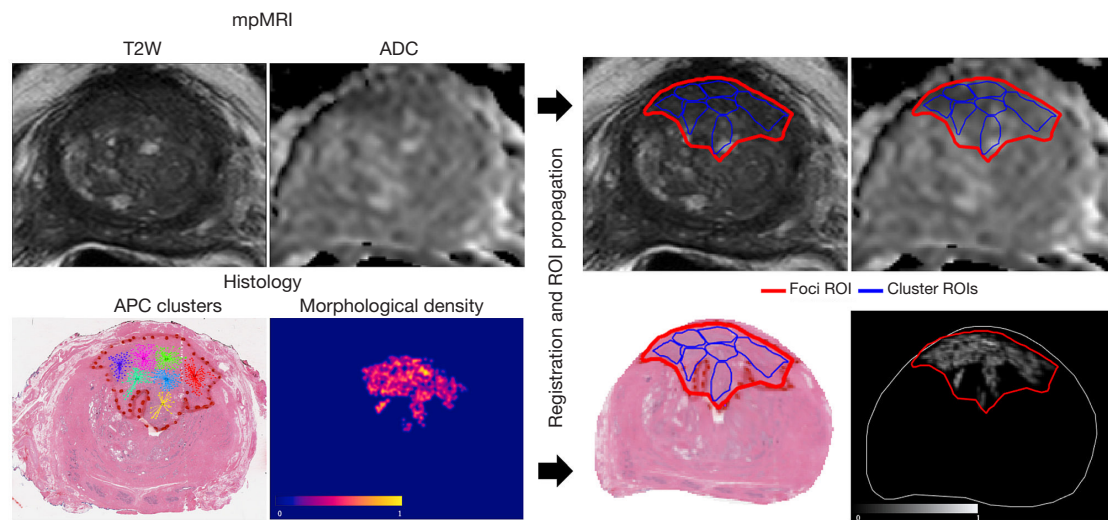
Example of large anterior lesion demonstrating diffusion restriction on mpMRI with heterogeneous morphology density spread over 7 intra-foci clusters. For quantification, boundary regions of the foci (red) and individual clusters (blue) were mapped to ADC. mpMRI, multiparametric MRI; ADC, apparent diffusion coefficient; ROIs, regions of interest.
